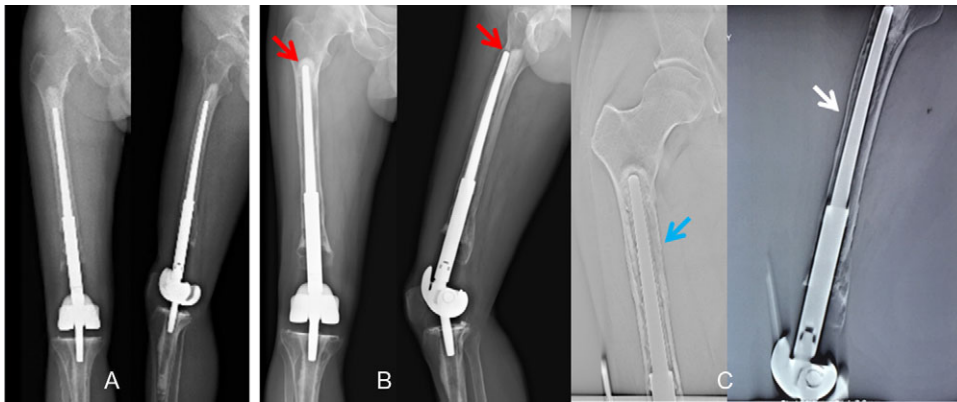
The preoperative radiographs of Patient 5 before revision surgery. (A) The postoperative anteroposterior and lateral radiograph immediately after the primary megaprosthesis reconstruction; (B) the preoperative anteroposterior and lateral radiograph before revision surgery, the red arrows show that the stem is not only aseptic loosening but also shift upwards for a long distance, and the anterior cortex of bone is very thin; (C) the T-SMART image before revision surgery, the blue arrow shows that there is bright line between the cement and the stem, the white arrow shows that the bone quality and quantity of anterior femoral bone is very thin for standard stem.
